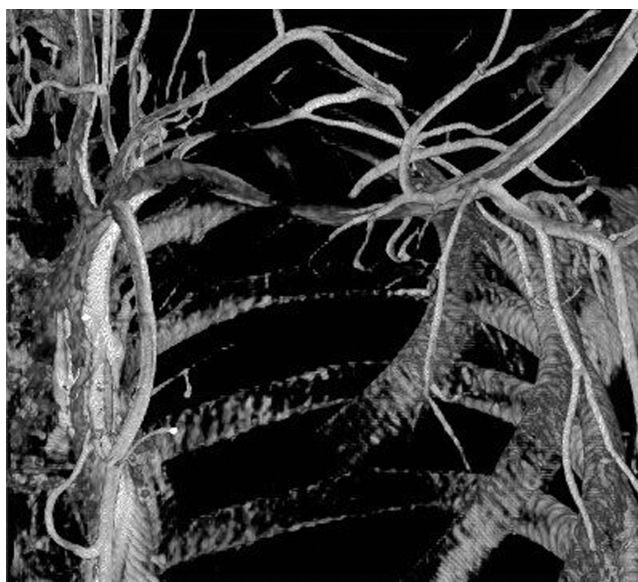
3D image demonstrating compression of the subclavian artery consistent with Paget-Schroetter syndrome. This cone-beam CT reconstruction was created from a single rotational acquisition with contrast injection via 5-French catheter positioned at the origin of the subclavian artery. Note: The clavicle has been manually removed from the image so that the critical narrowing can be seen.
